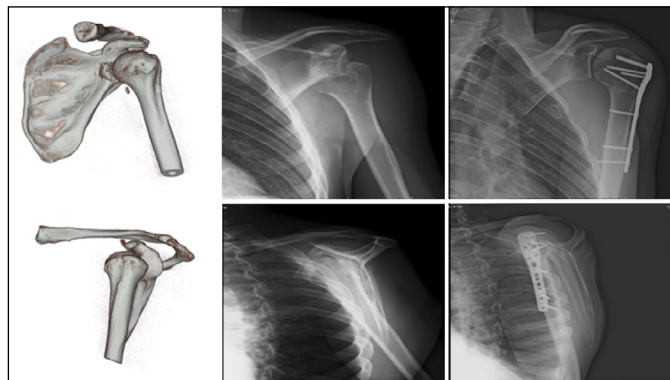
Tomography with 3D reconstruction and pre- and post-operative radiographs.
